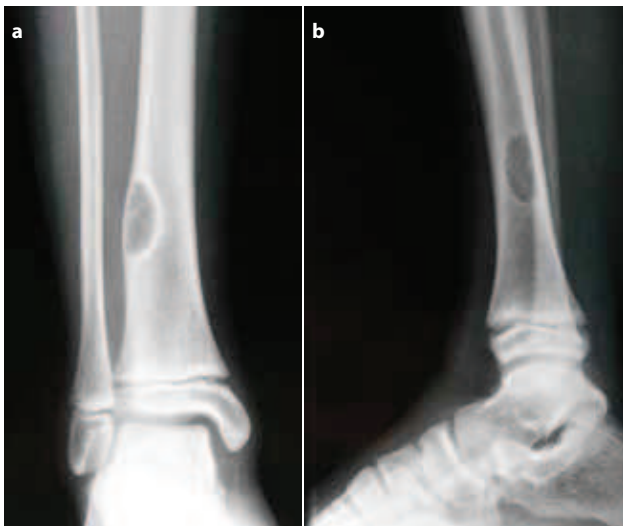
Anteroposterior and lateral X-rays of right distal tibia. An eccentric cortical lesion with sclerotic margins is noted.
